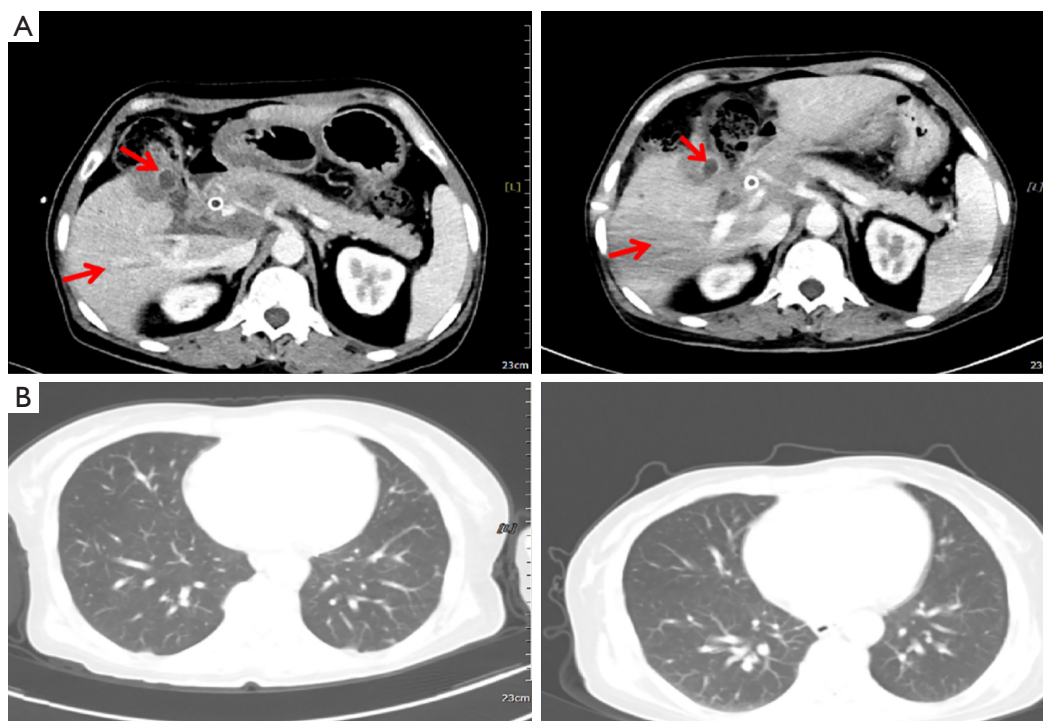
The patient's condition has improved. Significant changes indicated by red arrows. (A,B) Thoracic and abdominal enhanced CT was repeated after 10 (December 15, 2019) and 15 (March 23, 2020) cycles of chemotherapy, and lung lesions, gallbladder and liver lesions was stable. CT, computed tomography.
